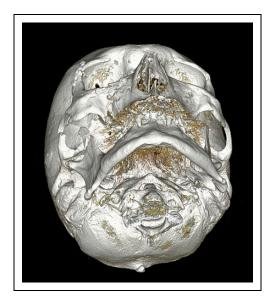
Early postoperative 3D-CT aspect.
